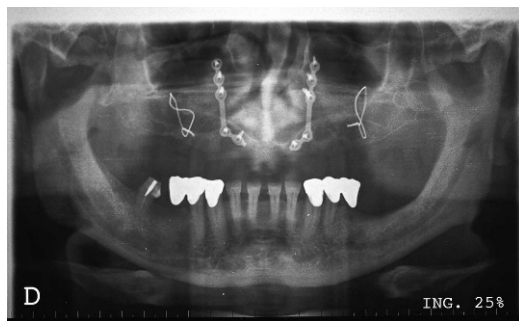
Orthopantomography showing the inlay bone graft inserted into Le Fort I osteotomy.
